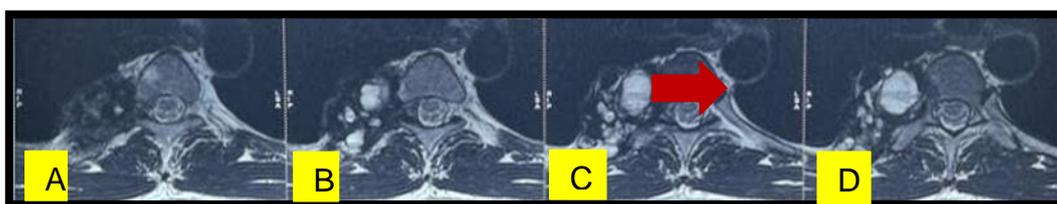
Image D showing radiographic finding of GCT involving rib
